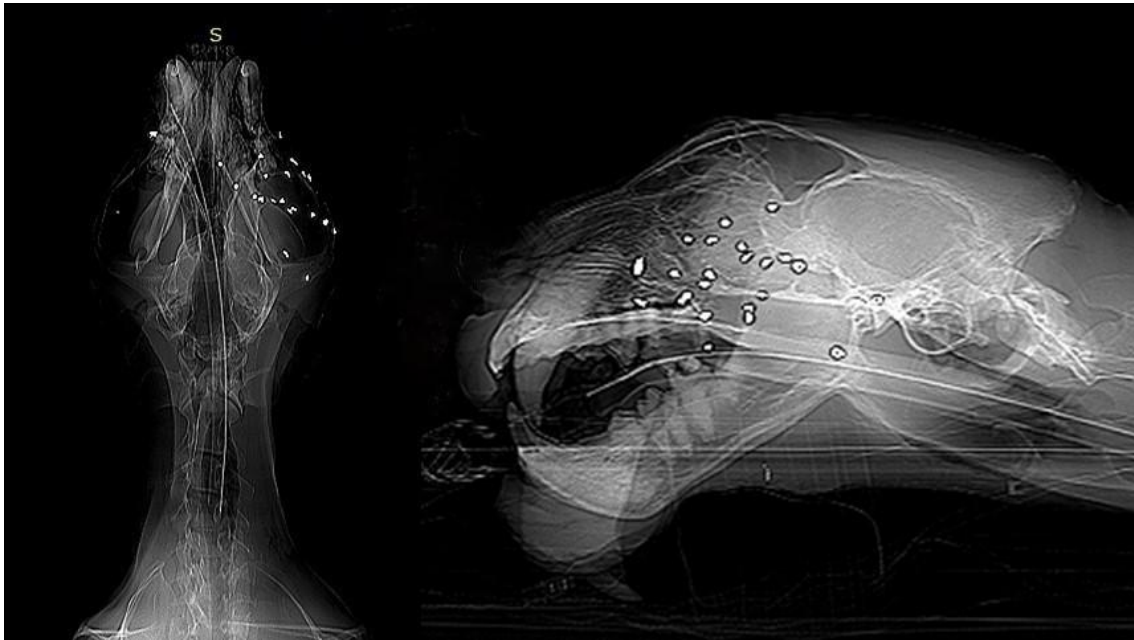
Jaguar (*Panthera onca*). Radiograph, ventro-dorsal and latero-lateral view. Right maxillary and zygomatic arch region with 21 radiopaque projectiles of approximately 0.5 cm in diameter.
